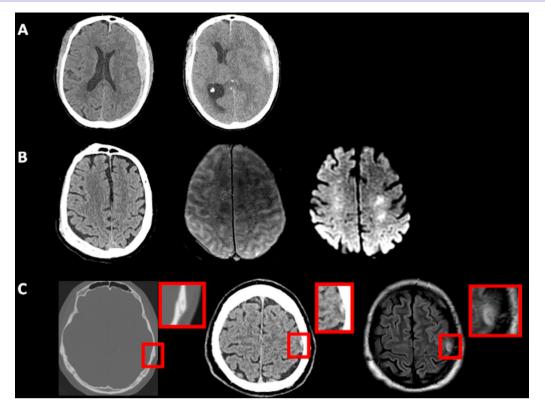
Examples of post-traumatic amnesia mimics and chameleons. (A) 72-year-old man with transient loss of consciousness and head injury. Initial CT scan of head showed left-sided subdural haemorrhage without mass effect. Two weeks later, there was a deterioration in conscious level with repeat imaging showing interval haemorrhage with effacement of the left lateral ventricle and midline shift towards the right. (B) An 87-year-old man who fell from a ladder and was initially lucid followed by a reduction in conscious level in the ambulance on the way to the hospital. Initial CT scan of the head (left) showed no definite intracranial abnormality. Magnetic resonance scan of the brain subsequently showed multiple small foci on susceptibility weighted imaging (middle image) and restricted diffusion on diffusion weighted imaging (right image) throughout the whole brain, caused by fat embolism from a fractured femur. (C) A 36-year-old man was brought to the hospital by a friend who found him confused and repetitively asking questions. He had last been seen well the night before. There was no obvious evidence of head injury on examination, and he was provisionally diagnosed with transient global amnesia. Subsequent cranial imaging found a subtle transverse fracture spanning the sagittal suture, extending through both left and right parietal bones (left) with evidence of underlying contusions in the left postcentral gyrus on MRI (right), which could be seen with retrospect on the initial plain CT scan of the head (centre).
